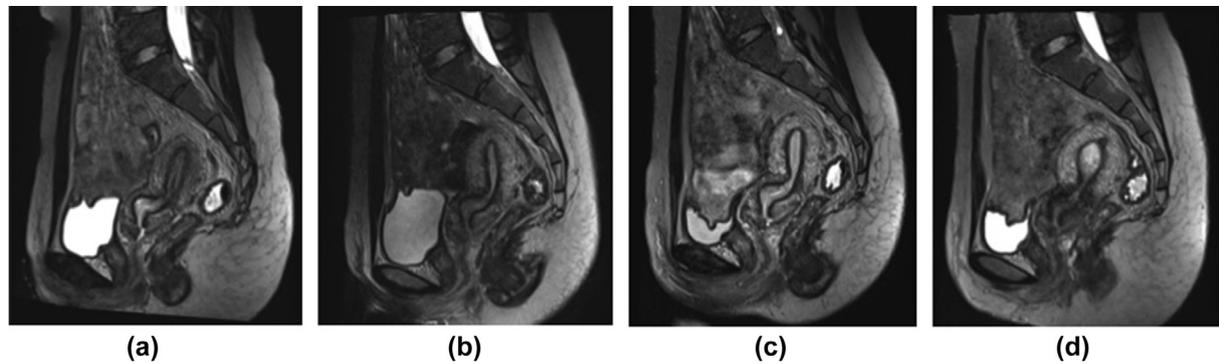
High-resolution 3D T2-weighted images in the mid-sagittal plane of a 28-year-old volunteer during the menstrual cycle including (a) MP; (b) FP; (c) OP; (d) LP. The boundary sharpness of the uterine three zonal structures was well-defined in all four phases.
